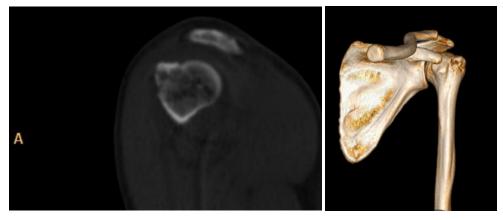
CT images showing minimally displaced greater tuberosity fracture - left
